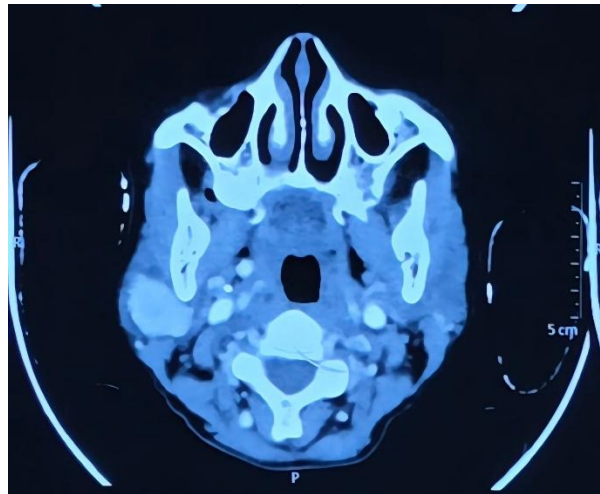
Contrast enhanced computed tomography sagittal sections showing a well-defined hypodense lesion arising from deep lobe of right parotid gland.
